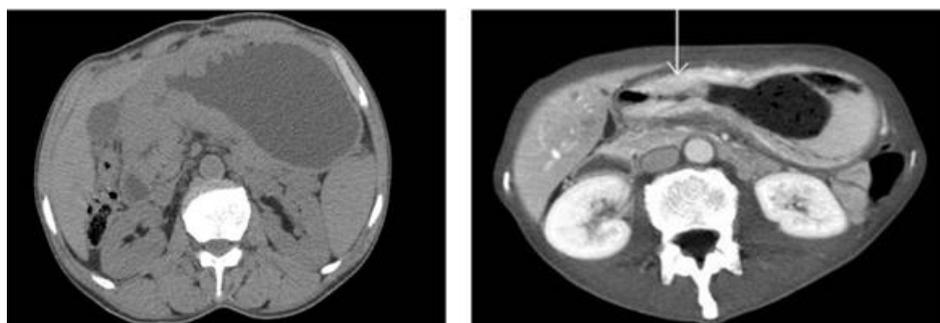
CT showing low density mural thickening with wall enhancement. A. NCCT, B. CECT.
